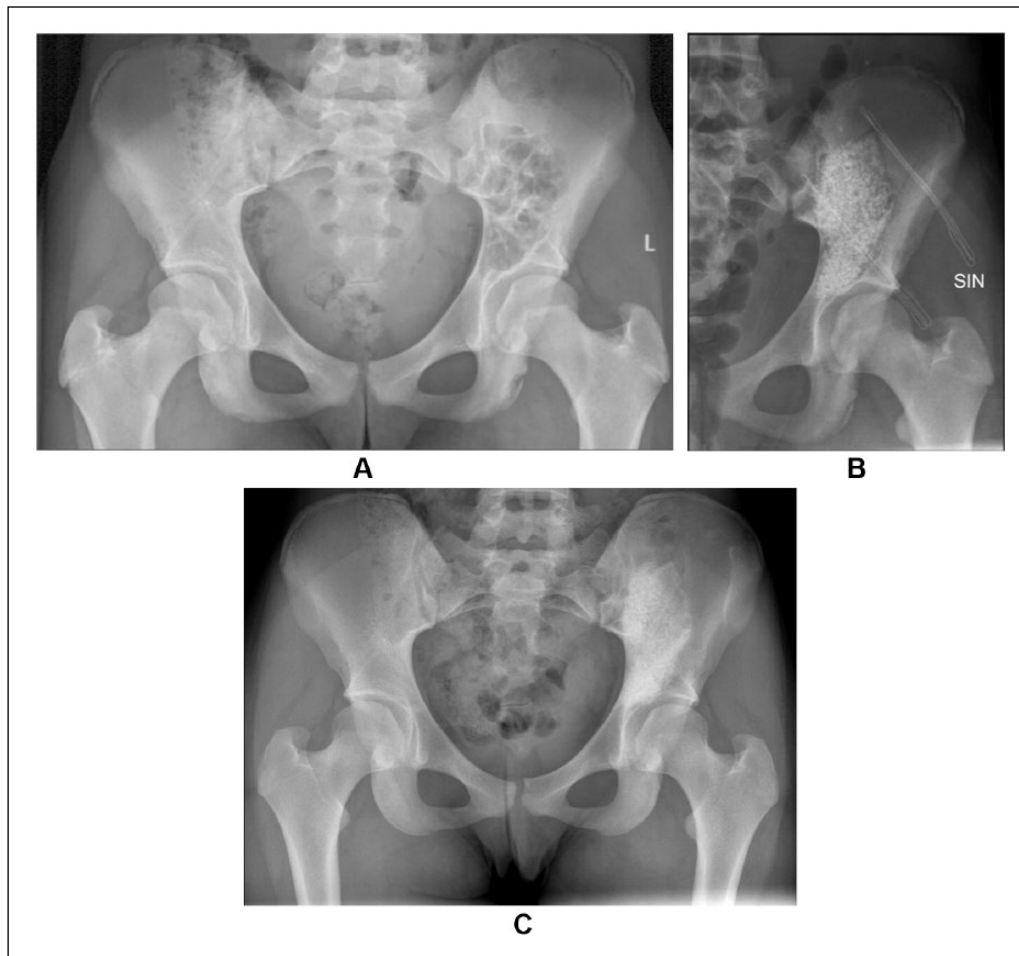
A) Preoperative radiograph from the patient who had massive aneurysmatic bone cyst of the pelvis. B) Immediate radiograph after curettage and bioactive glass filling. C) Three years from the curettage and bioactive glass filling.
